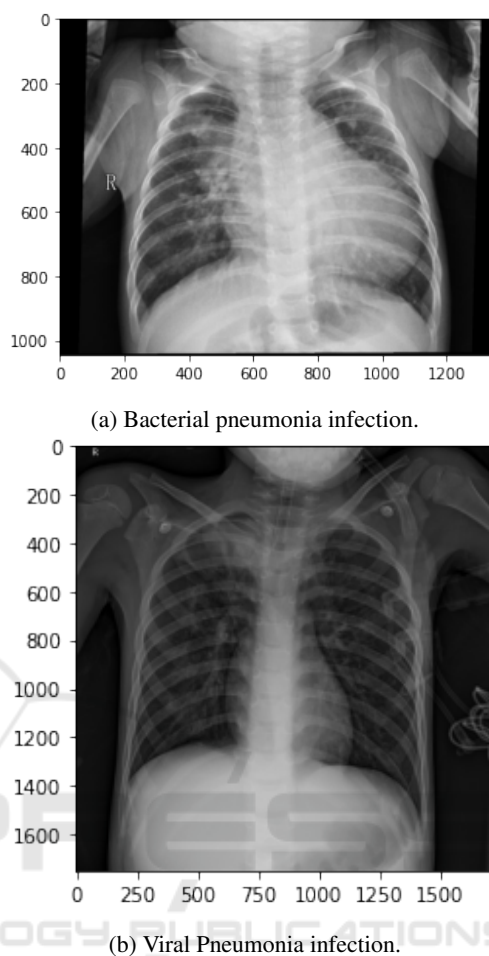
Example of chest radiography images of: (a) viral Pneumonia infected Lung filled with secretion of the white inflammatory fluid, and (b) viral Pneumonia infected Lung with white spots.
